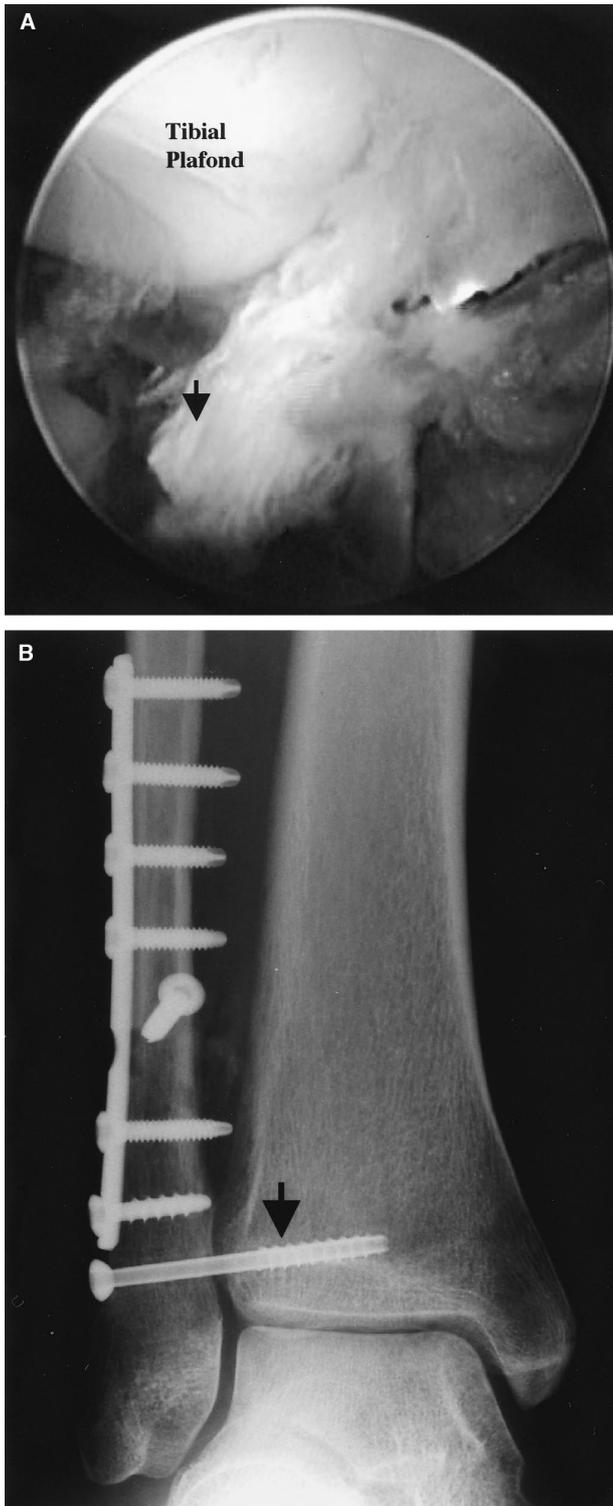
(A) Arthroscopic finding of disrupted AITFL on the right ankle. The arthroscope was inserted at the anteromedial portal. The arrow indicates that the AITFL was torn at its fibular attachment, found by palpation with a probe. (B) Standard anteroposterior radiograph of the right ankle after syndesmosis screw fixation. The arrow indicates a syndesmosis screw penetrating the three cortices only.
